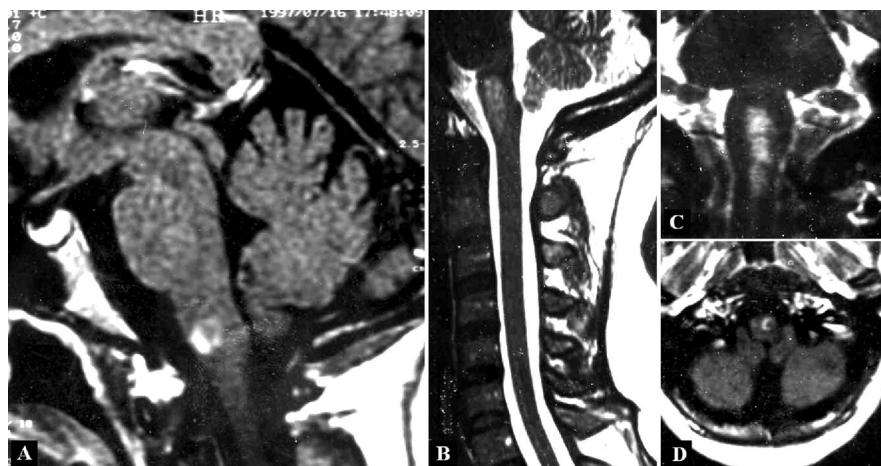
MRI scans. An area of abnormal signal, probably of demyelinating origin, is evident in the upper medulla and pons. No other signal abnormalities are evident within the CNS; in particular, the cervical cord is spared (B).
